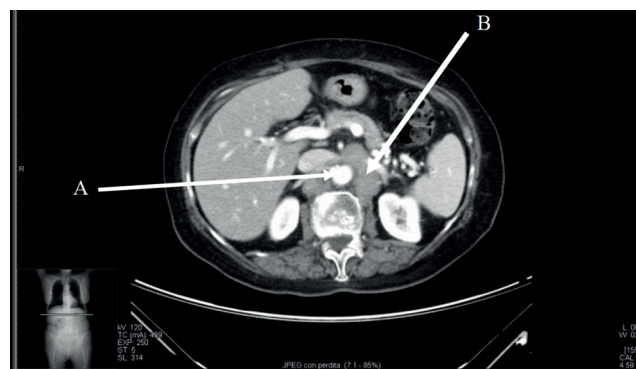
Abdomen computed tomography scan image showing a normal size aorta (A) and enlarged para-aortic lymphnodes (B).
